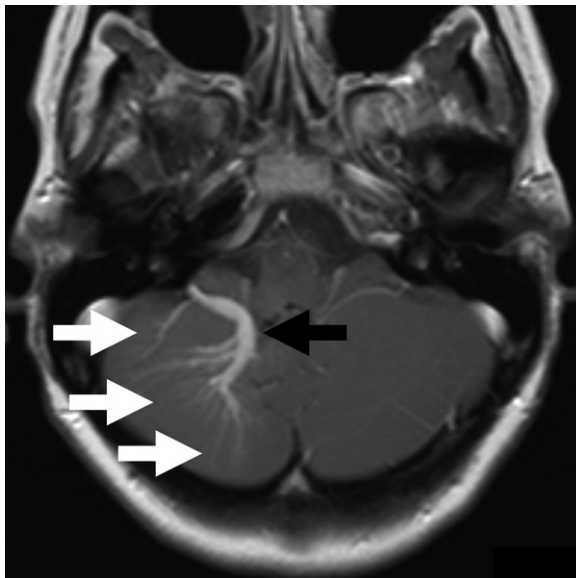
Example of a developmental venous anomaly MRI of an asymptomatic patient. Contrast-enhanced T1-weighted image shows abnormal blood vessels passing through the right cerebellar hemisphere. Various blood vessels (white arrows) unite to a larger collecting vein (black arrow), resembling the head of the goddess medusa or a palm tree. MRI: magnetic resonance imaging
